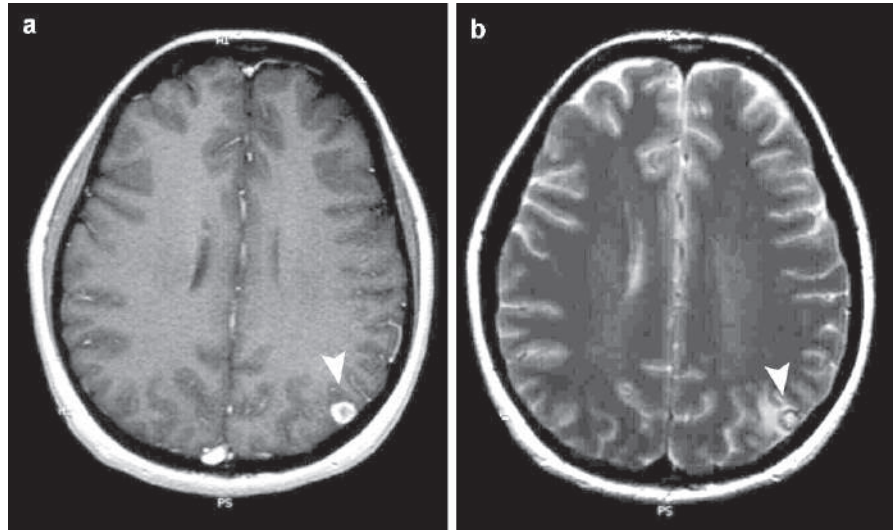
Axial T1W postcontrast (a) and T2W (b) brain MR images of colloidal stage neurocysticercosis (arrowheads)
